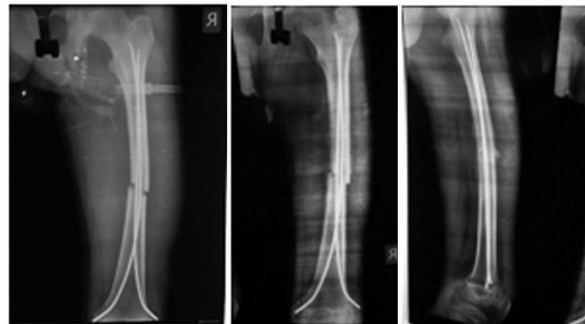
(b) immediate post-op x-ray,(c,d) x- ray after 8 weeks of operation.
